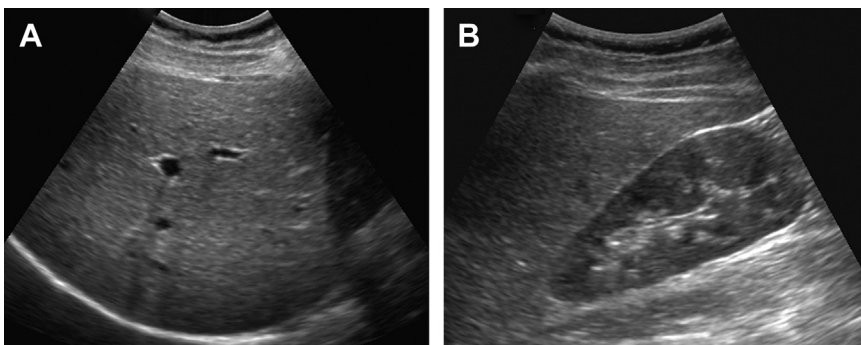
Normal liver ultrasonogram. (A) Transverse ultrasonography (US) shows homogeneous echotexture. (B) Sagittal image demonstrates that the liver echogenicity is slightly higher than that of the right kidney.
